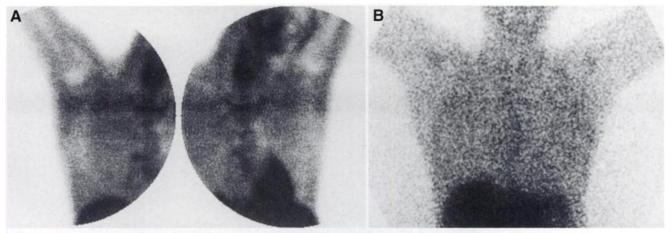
Anterior planar scintigram of patient 5 with fibrocystic disease. No focal uptake of either MIBI (A) or MIVE (B) was evident.
